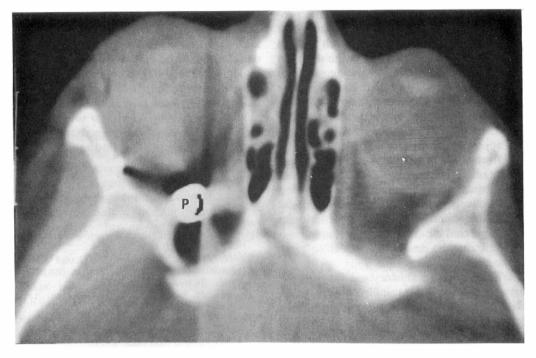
Axial CT-Scan cut through the orbits demonstrating an airgun pellet (P) lodged against the right optic nerve. Compare position of optic nerve in left orbit. (Note streak artefacts radiate from the metallic pellet, being most prominent through the medial right globe).
